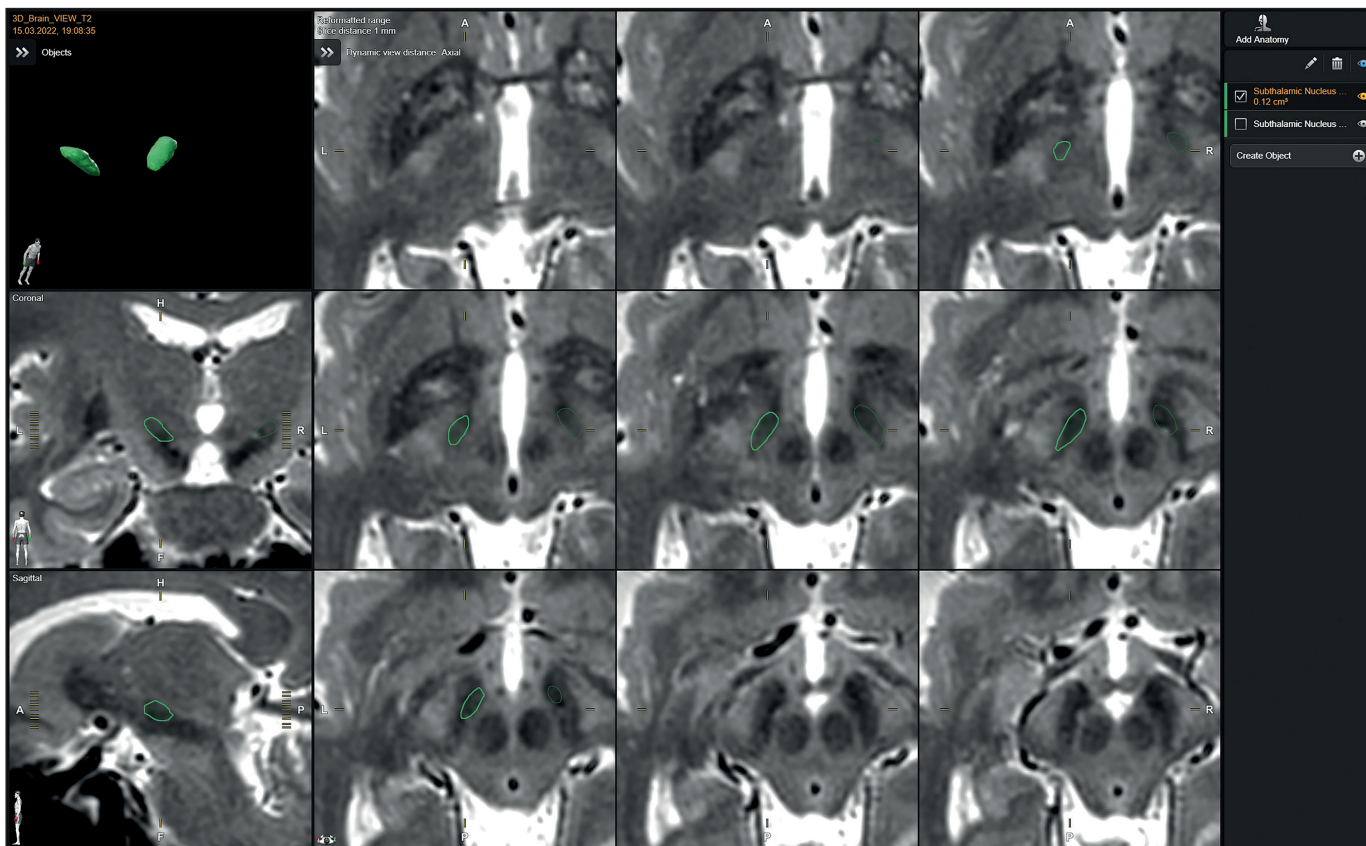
Segmentation of Left STN on T2 MR image. STN boundaries were determined in the automatic segmentation module of BrainLab elements software. Afterward, the errors were fixed manually. Finally, the STN volume was recorded.
